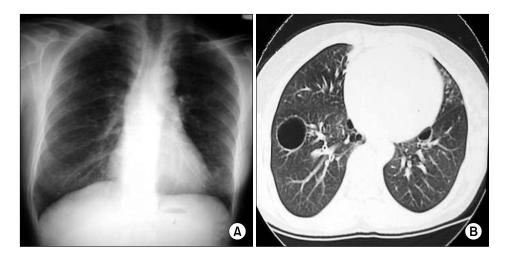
Chest radiographs and computed tomography at initial visit. (A) Chest radiographs showing bilateral multiple cysts, and (B) chest CT showing multiple well-demarcated, variable-sized cystic lesions in both lung fields.
